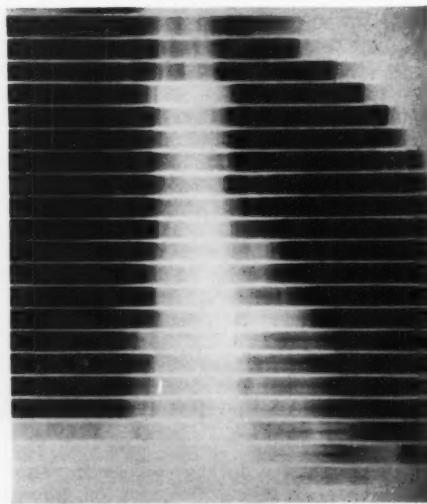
Roentgenkymogram showing marked pulsations of the main pulmonary artery that are greater than those of the aorta.
